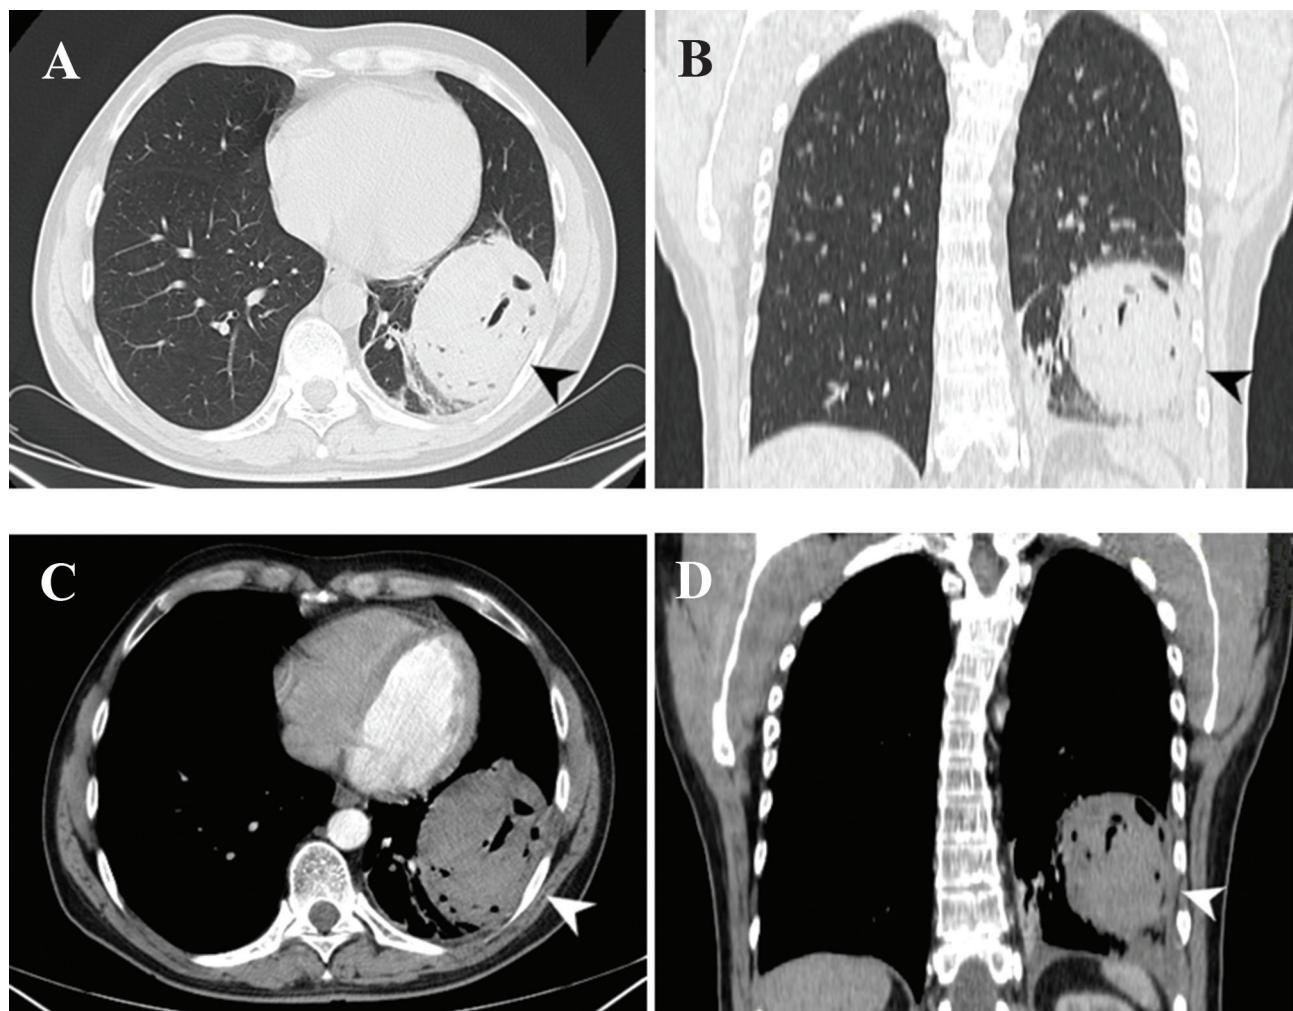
Axial and coronal CT images, visualizing left lower lobe synovial sarcoma.
